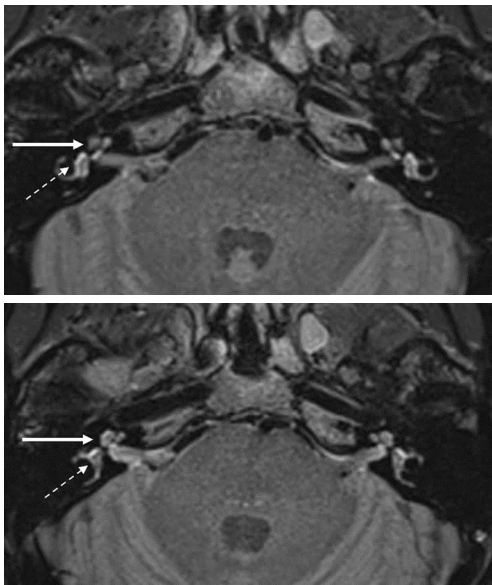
Postcontrast delayed 3D-FLAIR MRI revealing normal signal intensity in the perilymph of the bilaterally vestibule and cochlea. The white solid arrows indicate the cochlea, and the white dashed arrows indicate the vestibule. 3D-FLAIR MRI, 3-dimensional fluid-attenuated inversion recovery magnetic resonance imaging.
